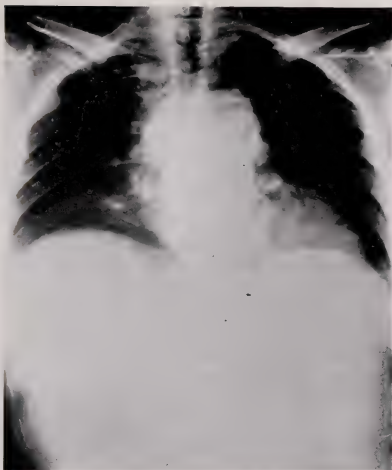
Chest X-ray showing extensive calcification of the posterior mediastinal nodes.
